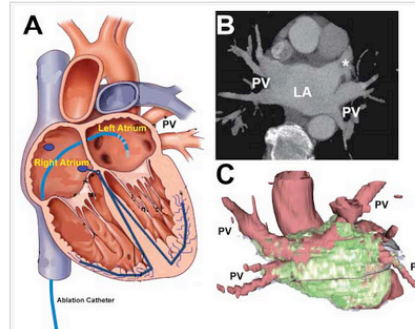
A The platinum-tipped catheter connected to the radiofrequency (RF) energy generator is advanced into the left atrium (LA) to the wall of the chamber, where bursts of RF energy ablate small regions of tissue. B CT of LA and pulmonary veins (PV). C Slicer-created image showing posterior view of segmentation of the LA, aorta, and PV (red) and superimposed segmentation of regions of late gadolinium enhancement (LGE)(green) from post-ablation MRI.
